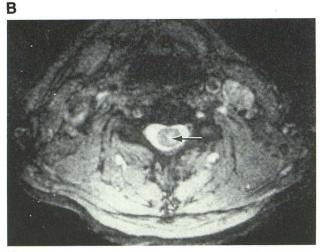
A, Sagittal gadolinium-enhanced, T1-weighted spin-echo image, 600/20/4 (TR/TE/excitations) demonstrates enhancement in the cervical cord due to inflammation caused by the herpes zoster infection (*arrows*). The *arrowhead* indicates the involvement of the anterior portion of the cord.
